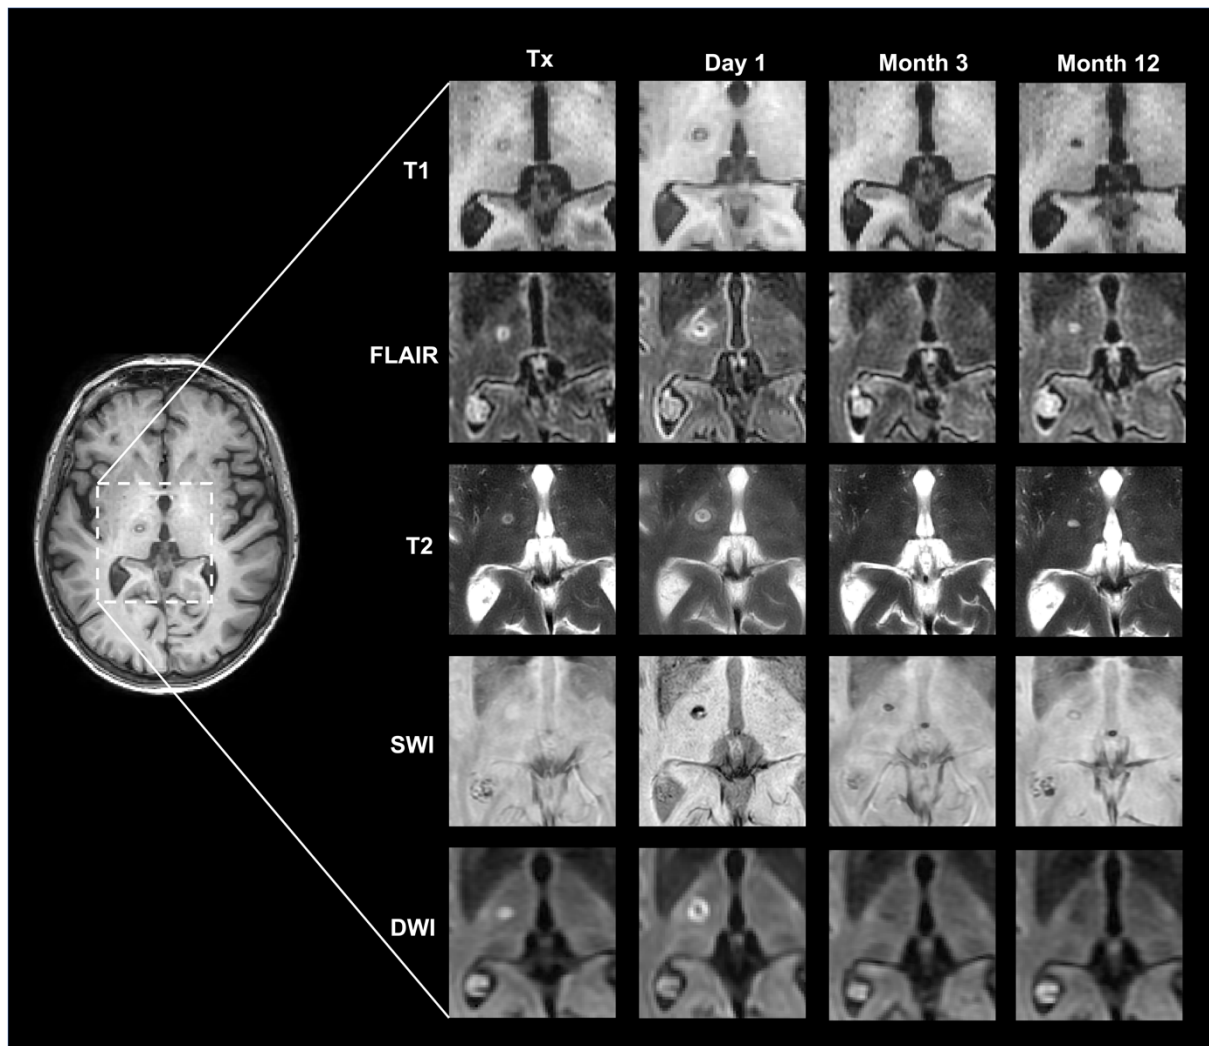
Evolution of tcMRgFUS lesion on MRI over a period of 12 months.
